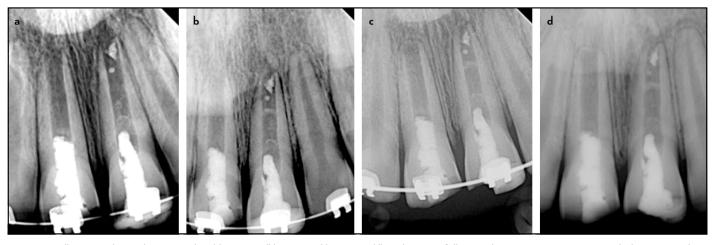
Follow up radiographs acquired at (a) 2 years, (b) 3 years, (c) 4 years, (d) and 5 years following the primary regenerative endodontic procedure
